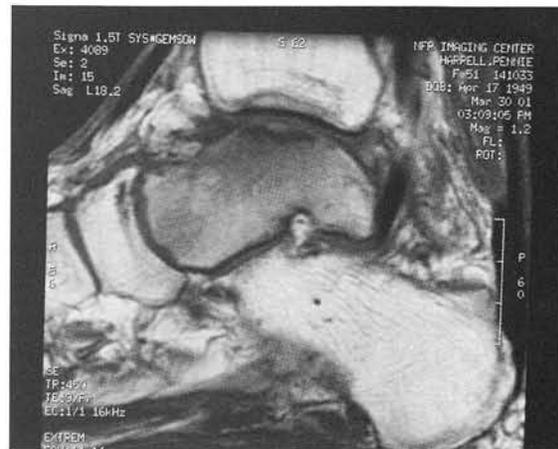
Pretreatment sagittal T1-weighted image showing decreased signal intensity immediately inferior to the articular surface dorsally with altered signal intensity surrounding the area.
